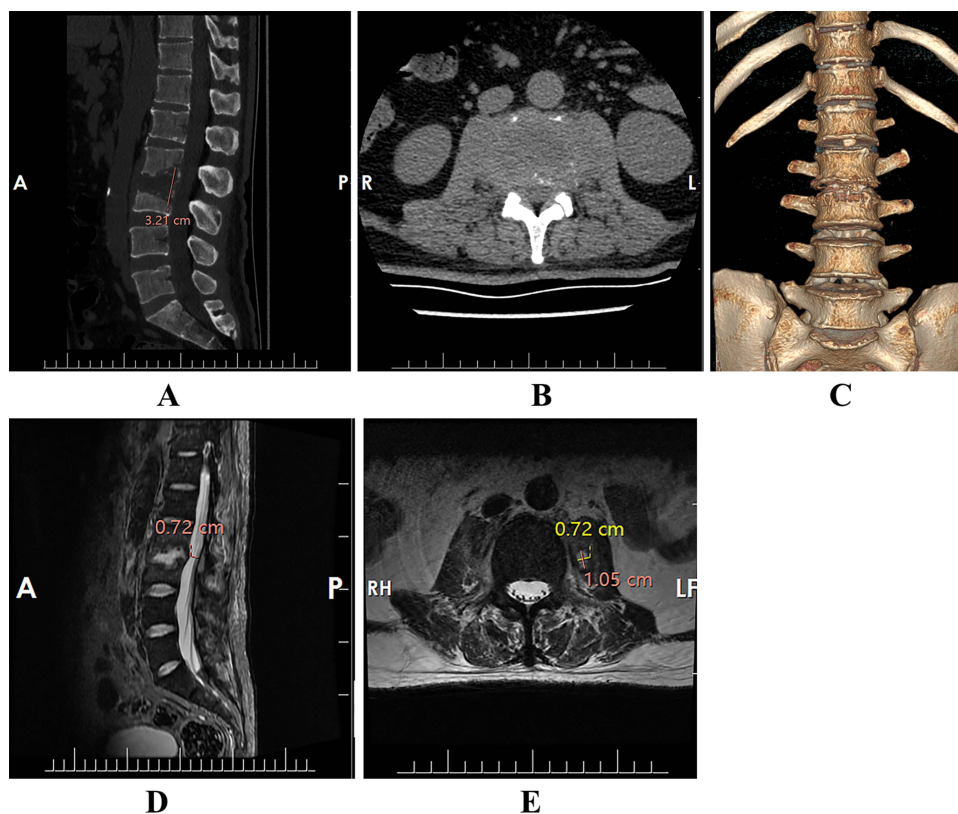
Preoperative follow-up CT and MRI. The scans show progressive destruction of the endplates at the L2/3 vertebrae. (A–C) Preoperative follow-up sagittal, axial CT scans, and 3D reconstruction of the lumbar spine reveal worsening vertebral bone destruction at the L2/3 level, with the maximum height of vertebral destruction measuring 3.21 cm. (D and E) Preoperative follow-up sagittal and axial lumbar spine MRI scans confirm the CT findings. The disc height is reduced by approximately 50%, with the narrowest point of the spinal canal measuring about 0.72 cm, and the largest paraspinous abscess has a maximum diameter of 0.72 * 1.05 cm.
